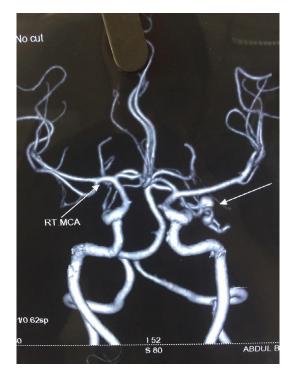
Computed tomography angiogram with 3D reconstruction showing the location of aneurysm
